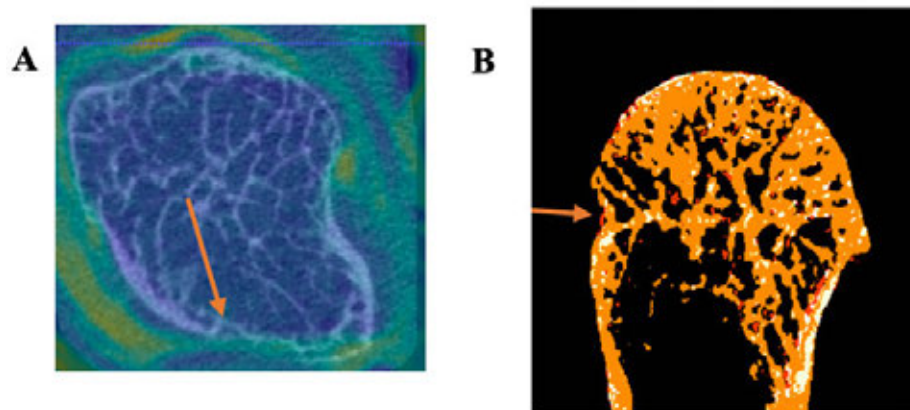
(A) An erosion in HR-pQCT (bone = white) overlaid with MR image indicating no evidence of inflammation at the site of the erosion at baseline. (B) When baseline and follow-up HR-pQCT images are registered and aligned to visualize bone loss and gain, there is evidence of bone formation (red) at the erosion. This erosion showed a decrease in volume over 6 months. Orange indicates stable bone while white indicates resorbed bone.
